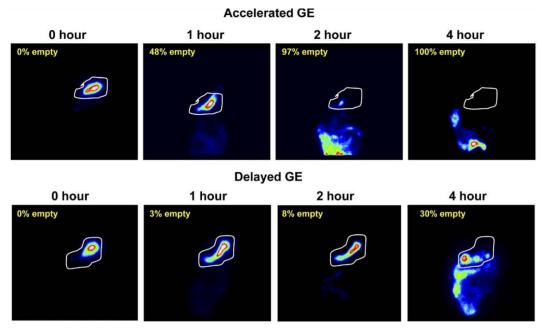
MRI scan results of gastric system in a GES test immediately after test meal ingestion for patients with gastric conditions
